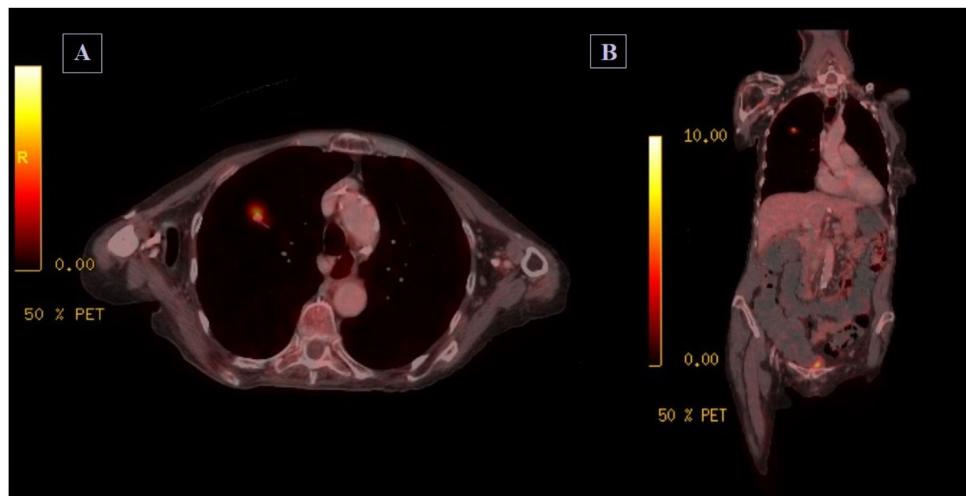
PET-CT images (Positron emission tomography co-registered with computarized tomography). Axial (A) and coronal (B) sections. Hypermetabolic pulmonary nodule in the right upper lobe, suggestive of malignancy.
